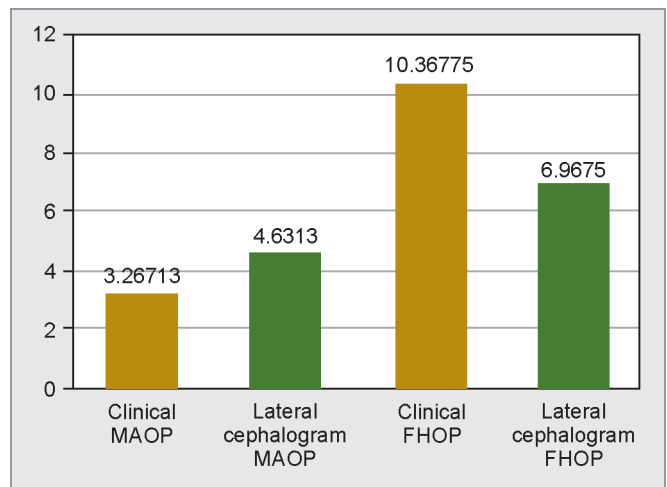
Comparison of clinical and radiographic reading with occlusal plane (using student one sample t-test)
